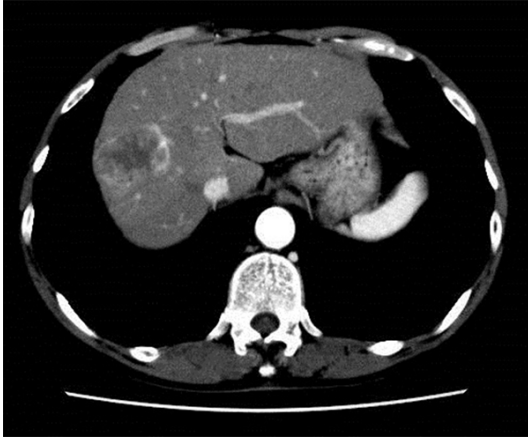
Enhanced computed tomography showed a 51 mm-in-diameter low-density area in liver segment 8. It appeared to have a lobular pattern.
